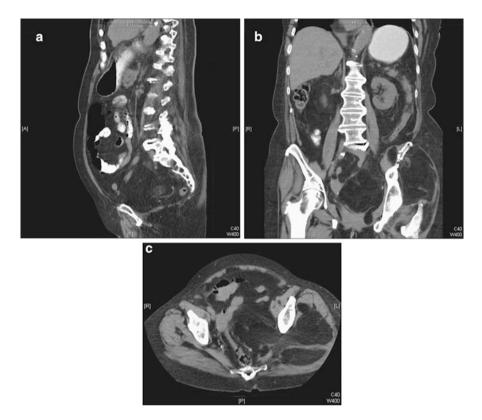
CT scan (a-c) of extensive well-differentiated liposarcoma, extending through the pelvis into the buttock. The sarcoma has nearly the same radiological density as normal fat
